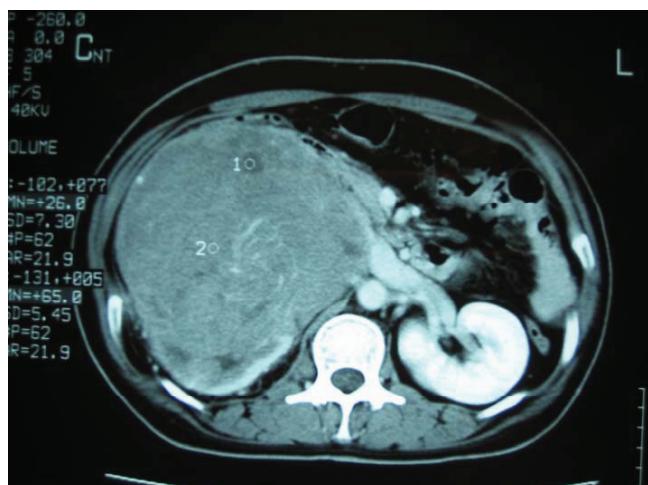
Computed tomographic scan shows a large heterogeneous enhancing mass of right kidney with inferior vena cava thrombus
